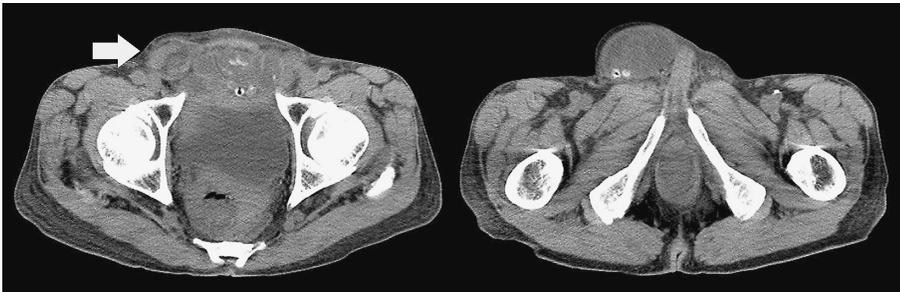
Computed tomography findings. A computed tomography scan showed that the sac of the right inguinal hernia contained the vermiform appendix (white arrow).
